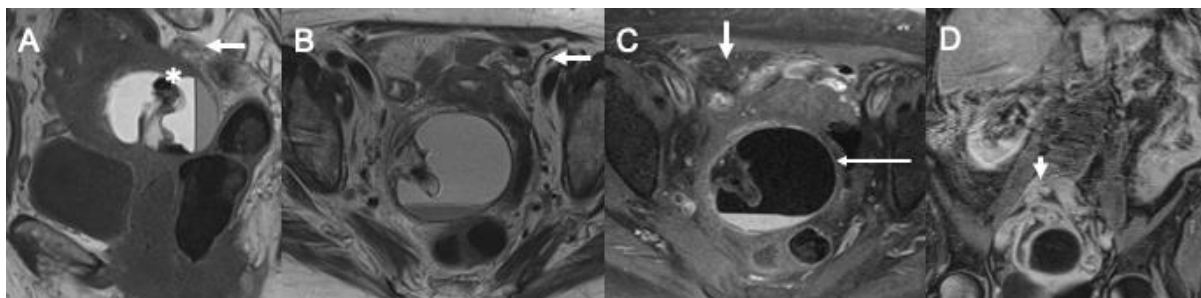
MRI of ovarian torsion due to MCT. MRI (A: T1-weighted; B: T2-weighted; C: axial T1-contrast; D: coronal T1-contrast) shows a cystic lesion consistent with MCT (asterisk) with a lack of enhancement on post-contrast images (long arrow). In addition, there are associated fat stranding (short arrows) and a twisted pedicle (arrowhead).
